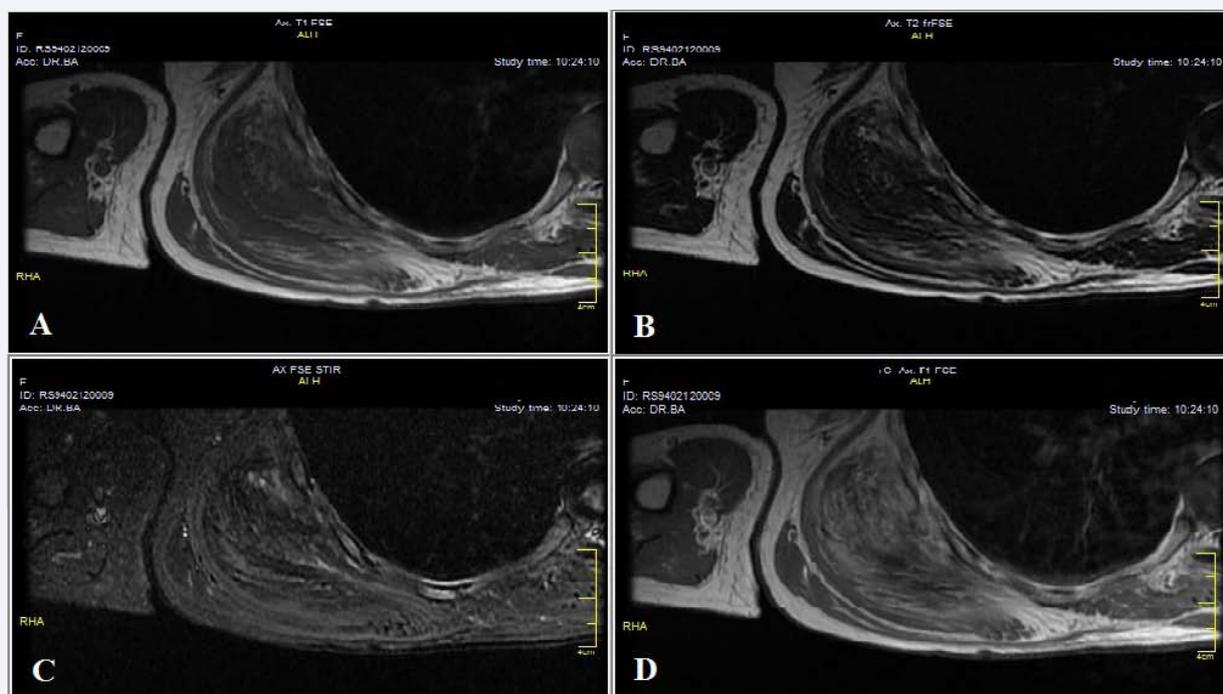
MRI shows an ill-defined soft tissue mass with intermediate signal on T1W (A) and low signal on T2W & STIR sequences (B&C) with minimal enhancement on T1W post contrast image (D) located in right infrascapular region beneath serratus anterior muscle without bony involvement. These findings are highly suggestive for elastofibroma dorsi.
